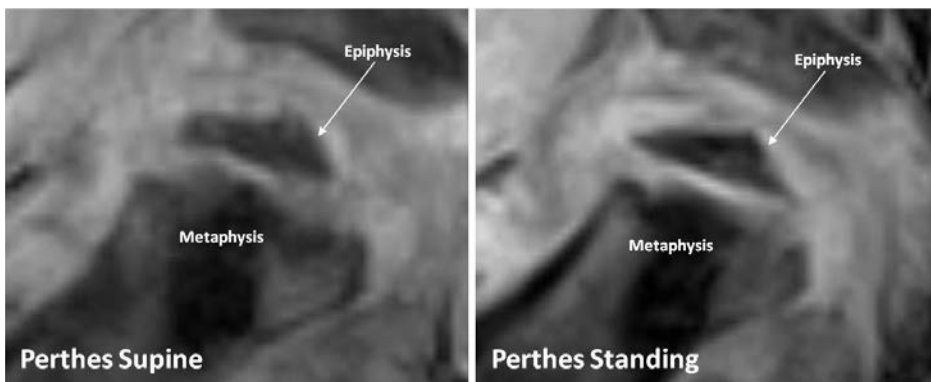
Comparative coronal MRI (TI GFE) of the right hip of a 5year old with LCPD in early fragmentation. The dynamic deformity of flattening, widening and increased lateral extrusion is demonstrated.
